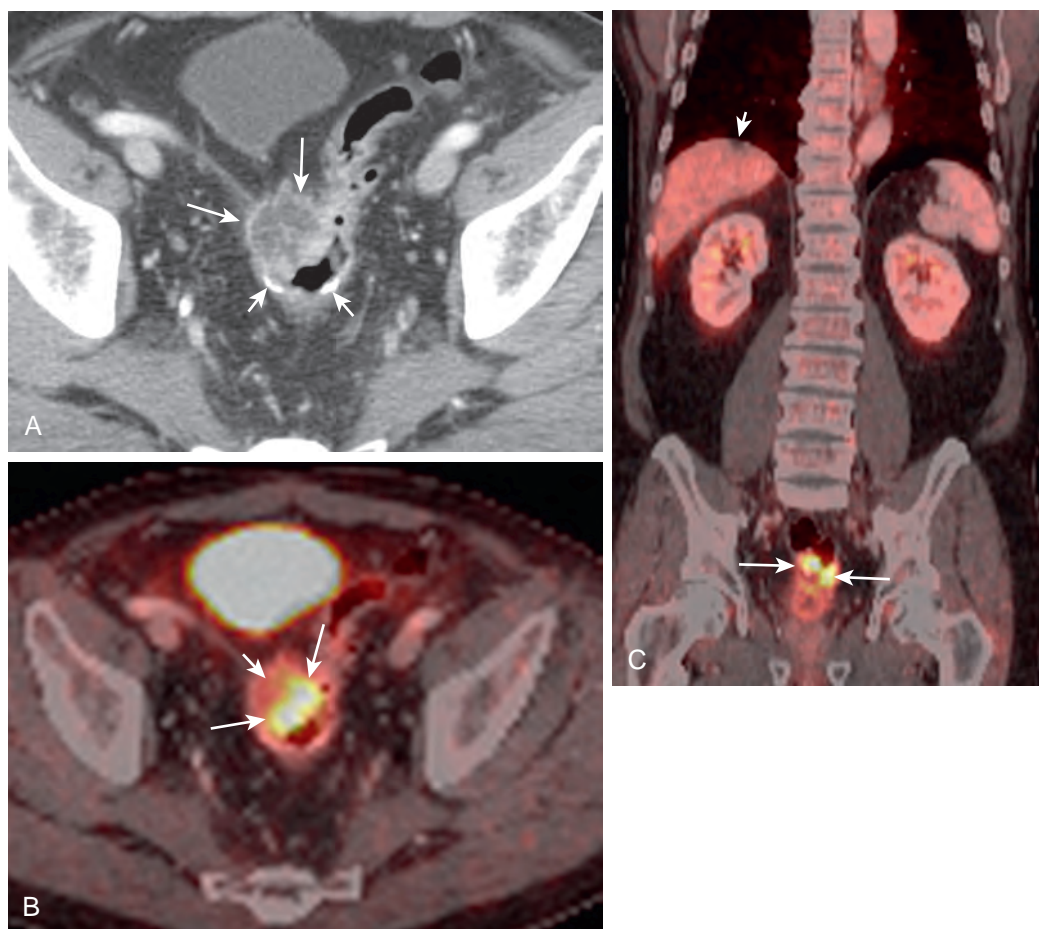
PET/CT scan of recurrence of tumor at the anastomosis in the rectosigmoid colon. This patient had undergone resection for sigmoid carcinoma and presents now with rising CEA levels. A. MDCT scan in the pelvis obtained in the axial plane demonstrates the partially necrotic recurrent tumor with a large extrinsic component (*large arrows*). The staple lines (*short arrows*) are also seen. B. The corresponding fusion image demonstrates markedly increased FDG uptake of the recurrent tumor at the anastomosis (*arrows*) but not in the necrotic component (*short arrow*). C. The coronal fusion image again demonstrates local recurrence (*long arrows*). A low-attenuation lesion seen on CT in the dome of the liver (*short arrow*) was not positive for a liver metastasis.
